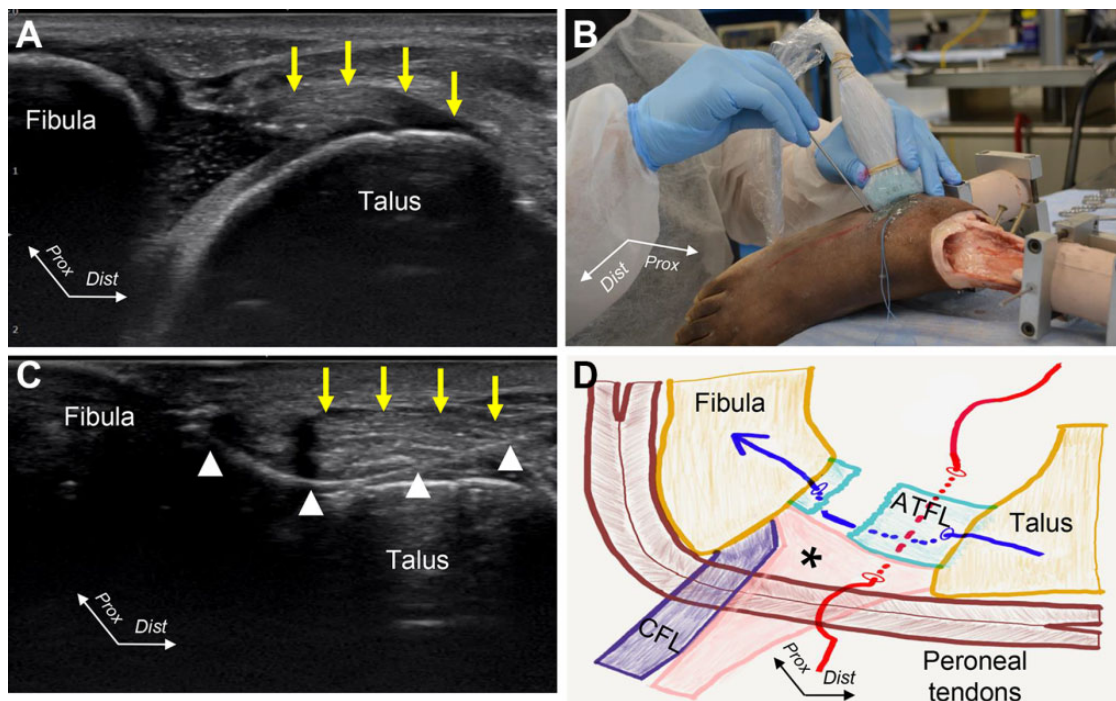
Ultrasound (US)-guided repair of the anterior talofibular ligament (ATFL). (A) The talar stump of the ATFL was visualized (yellow arrows) in the long axis view. (B and C) A MicroSutureLasso Minor Bend (white triangles) was introduced into the talar stump of the ATFL (yellow arrows) under US guidance. (D) The first suture (red line) penetrated the ATFL and the connecting fiber (black asterisk) between the ATFL and the calcaneofibular ligament (CFL). The second suture (blue line) passed through the long axis of the ATFL below the first suture. The 2 sutures were crossed perpendicularly. Dist, distal; Prox, proximal.
